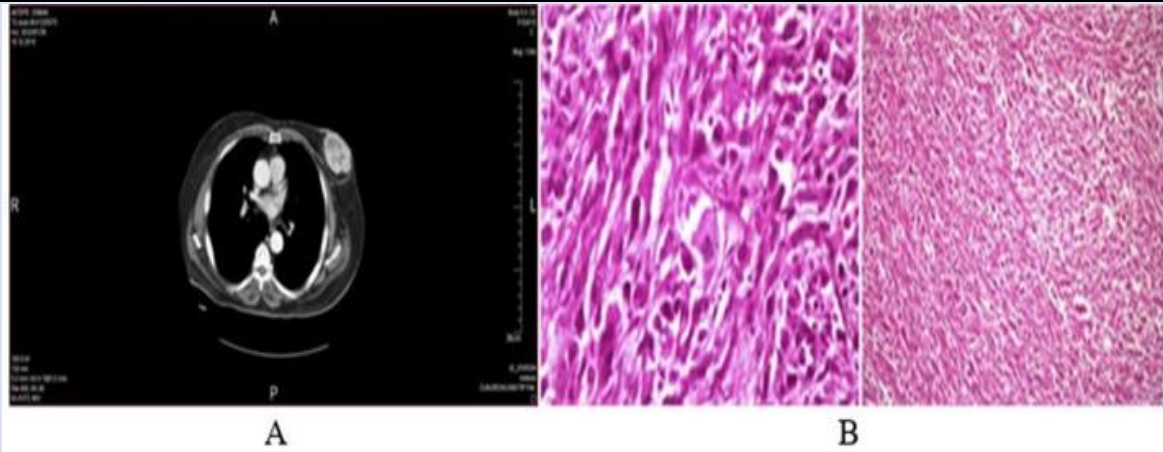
A computed tomography scans of the mass: Normal bilateral axilla the tumour mass in the left breast with high peripheral vascularity and hypodense necrotic centre.
